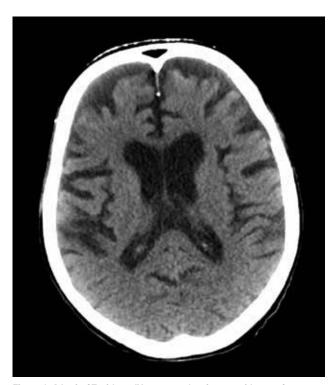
A brain CT without IV contrast showing no evidence of acute intracranial lesion. Dilated ventricles and prominent sulci are evident. Cerebral and cerebellar atrophy inappropriate for the patient's age is revealed.
